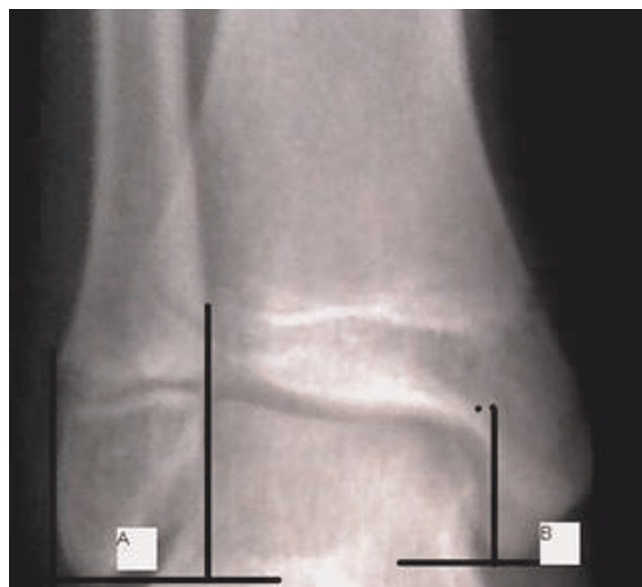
For evaluating the medial malleolus hypoplasia, the ratio between the length of the medial (B) and lateral (A) malleolus evaluated by the method of Elisé et al. [20] in anteroposterior ankle radiograph and it was found to be in normal ranges (0.62).
